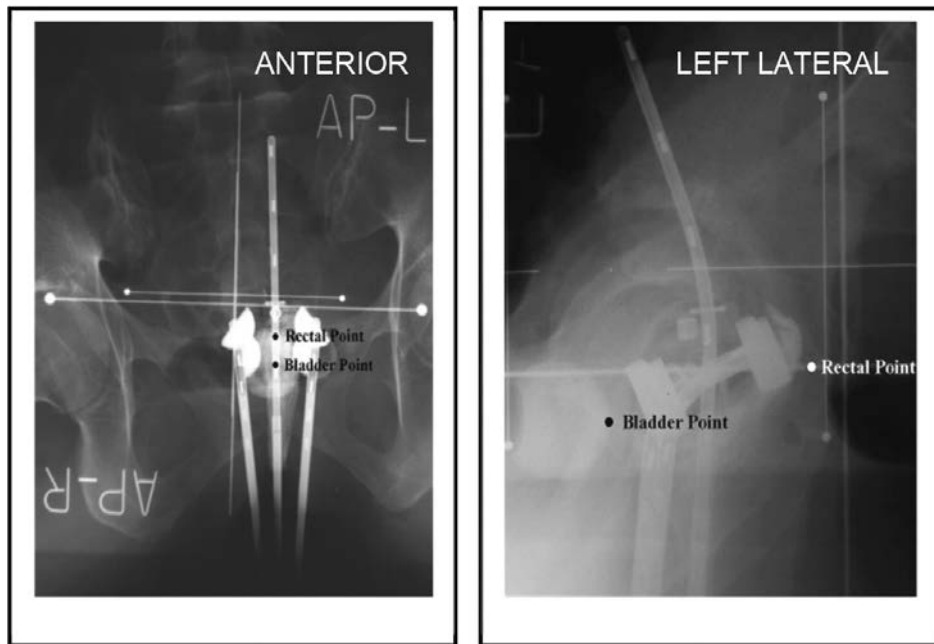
Anterior and lateral localization radiographs following insertion of applicators for HDR-BT. The following elements can be identified: tandem, vaginal ovoids with their shielding, metal ring in the external os, bladder Foley balloon, posterior vaginal packing and rectal and bladder calculation points.
